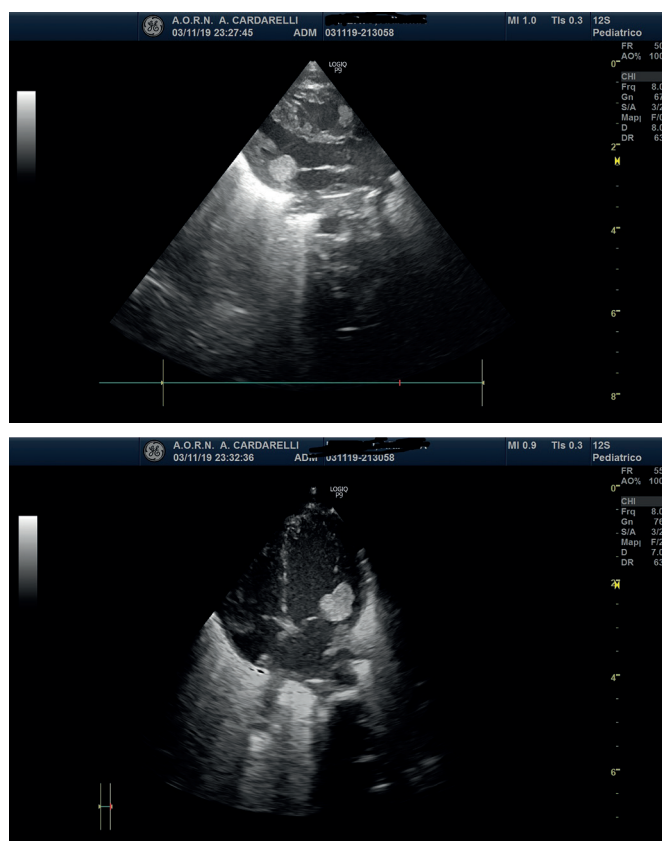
Heart ultrasound.
